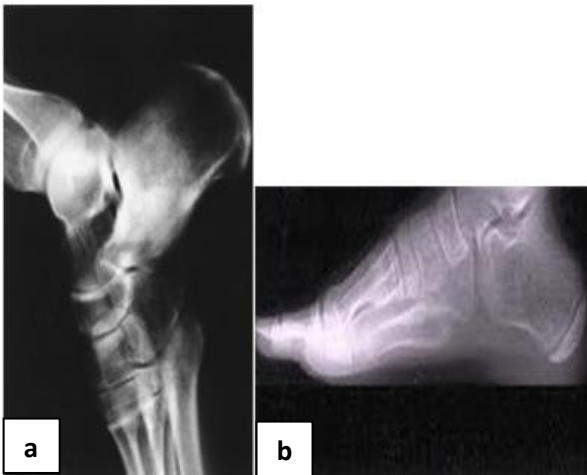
(a and b): X-ray of juxta articular osteoid osteoma.
